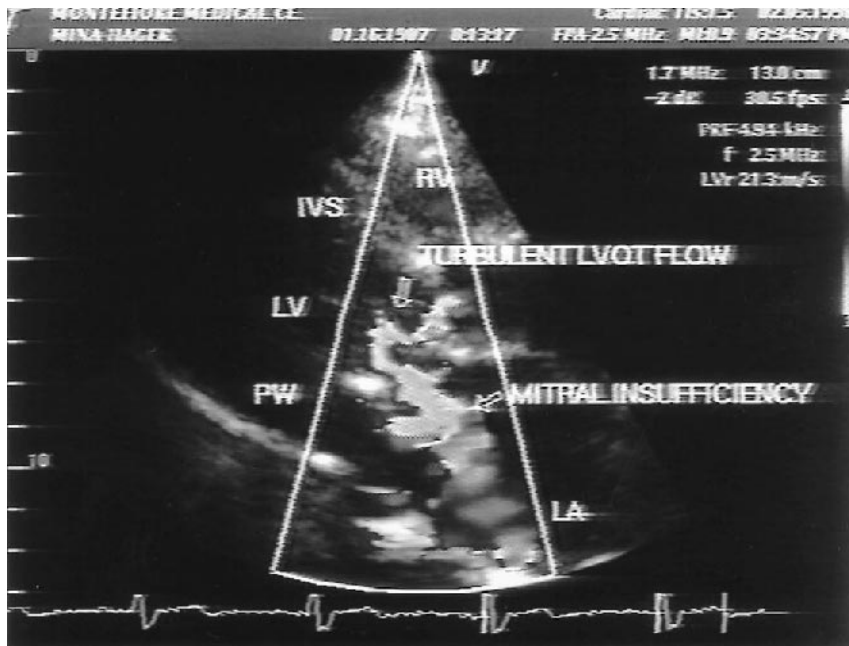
Color Doppler flow display superimposed on the same systolic frame from a parasternal long axis view shown in Figure 2, demonstrating turbulent LVOT flow. Abbreviations as in Figure 2.
